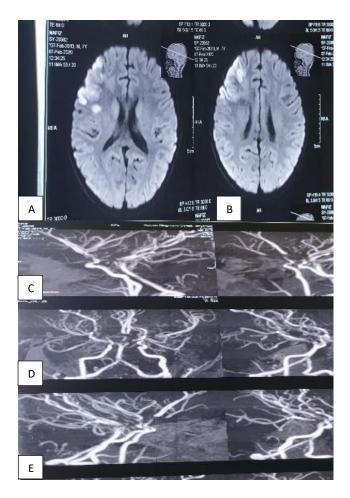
(A-E): MRI of brain including MRA of a 7-year-old child (Nafiz) with Moya Moya disease.
